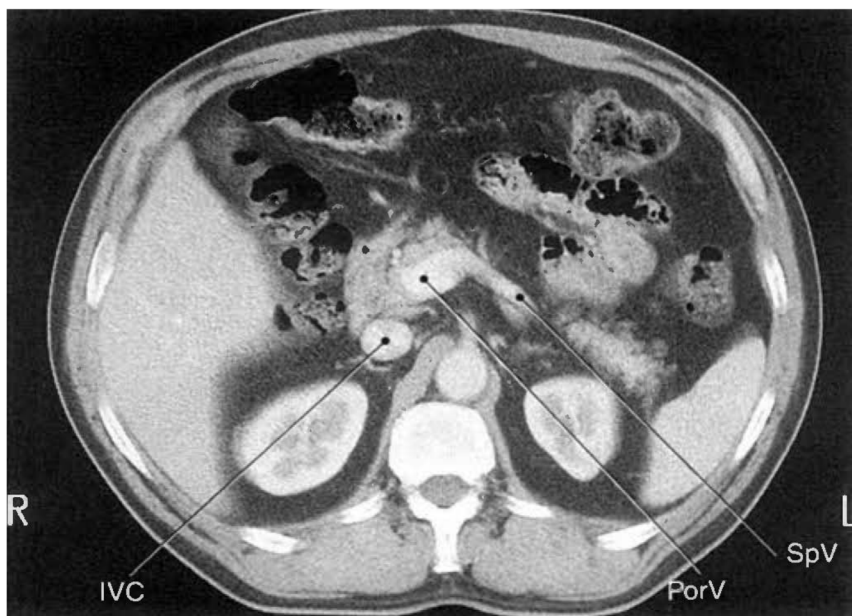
Axial CT scan of abdomen with portal and splenic veins. (Lorrie, 2007).
